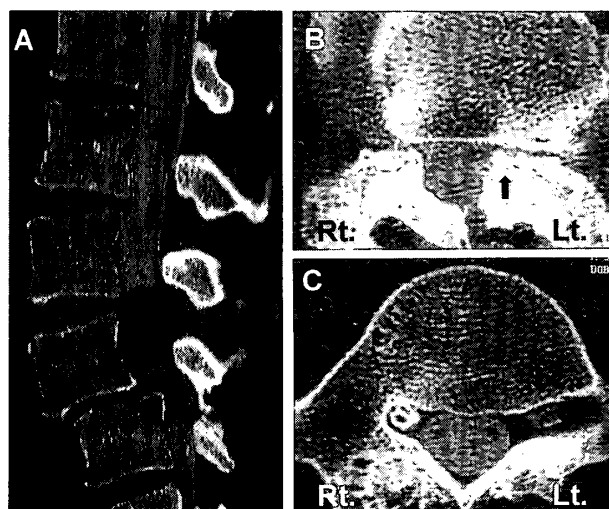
A, Postmyelogram three-dimensional reconstruction computed tomogram (CT) scan demonstrating a tumor at the L4 level. B, Postmyelogram computed tomography sections showing apparent compression of the left L5 spinal nerve root by the inferior articular processes of L4 of L4 vertebra. C, Computed tomography after myelography did not show left L5 spinal nerve root clearly.
